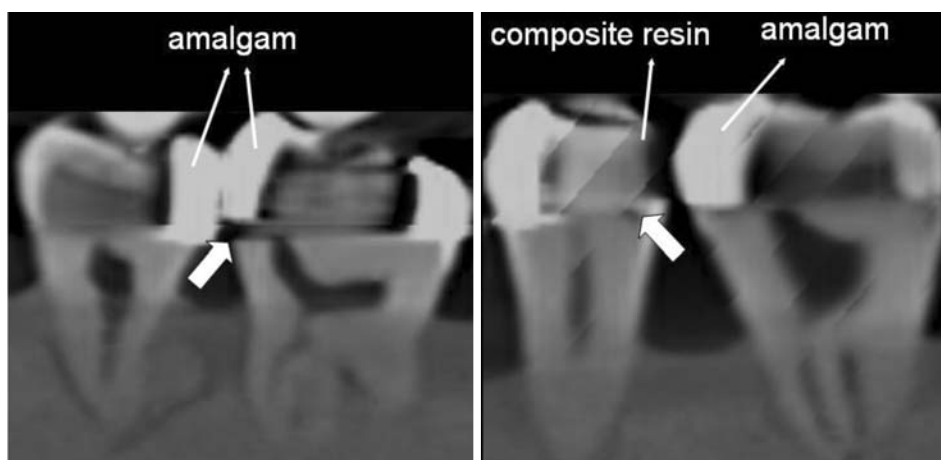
Examples of CBCT images in sagittal plane in which misinterpretation of secondary caries occurred. Thick arrows point at the surfaces that gave false positive results.
